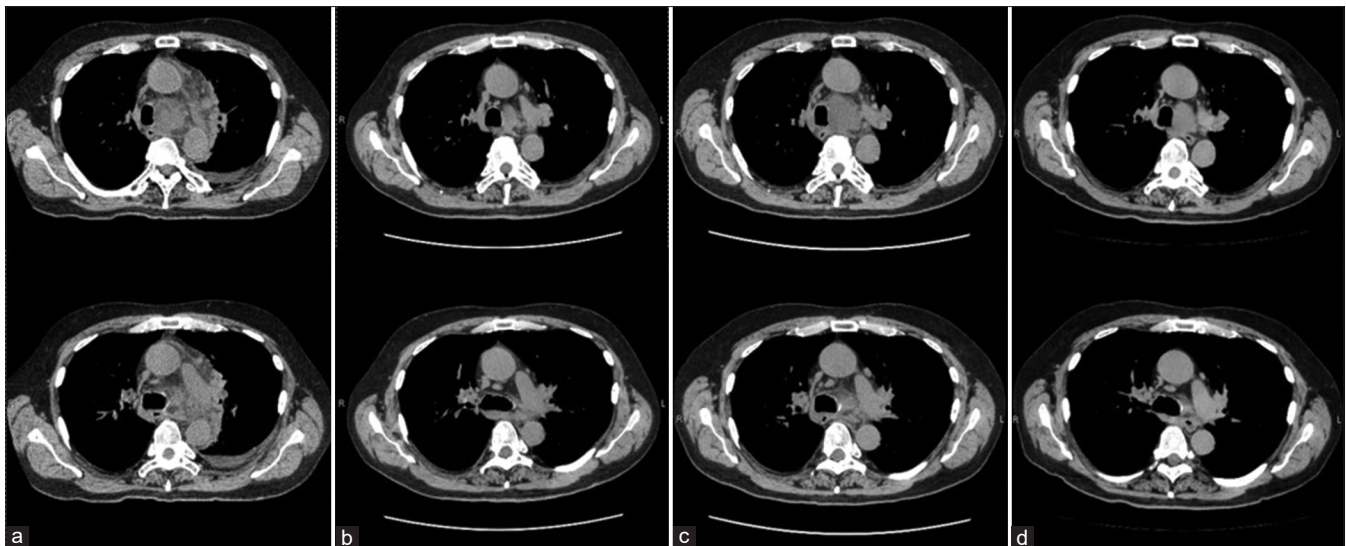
Section of an axial chest computed tomography scan of the 4 L lymph node. (a) Twelve days after endobronchial ultrasound-guide transbronchial needle aspiration. (b) Two months following the start of antimicrobial agents. (c) Five months following the discontinuation of antimicrobial agents. (d) Two weeks after restarting antimicrobial agents
